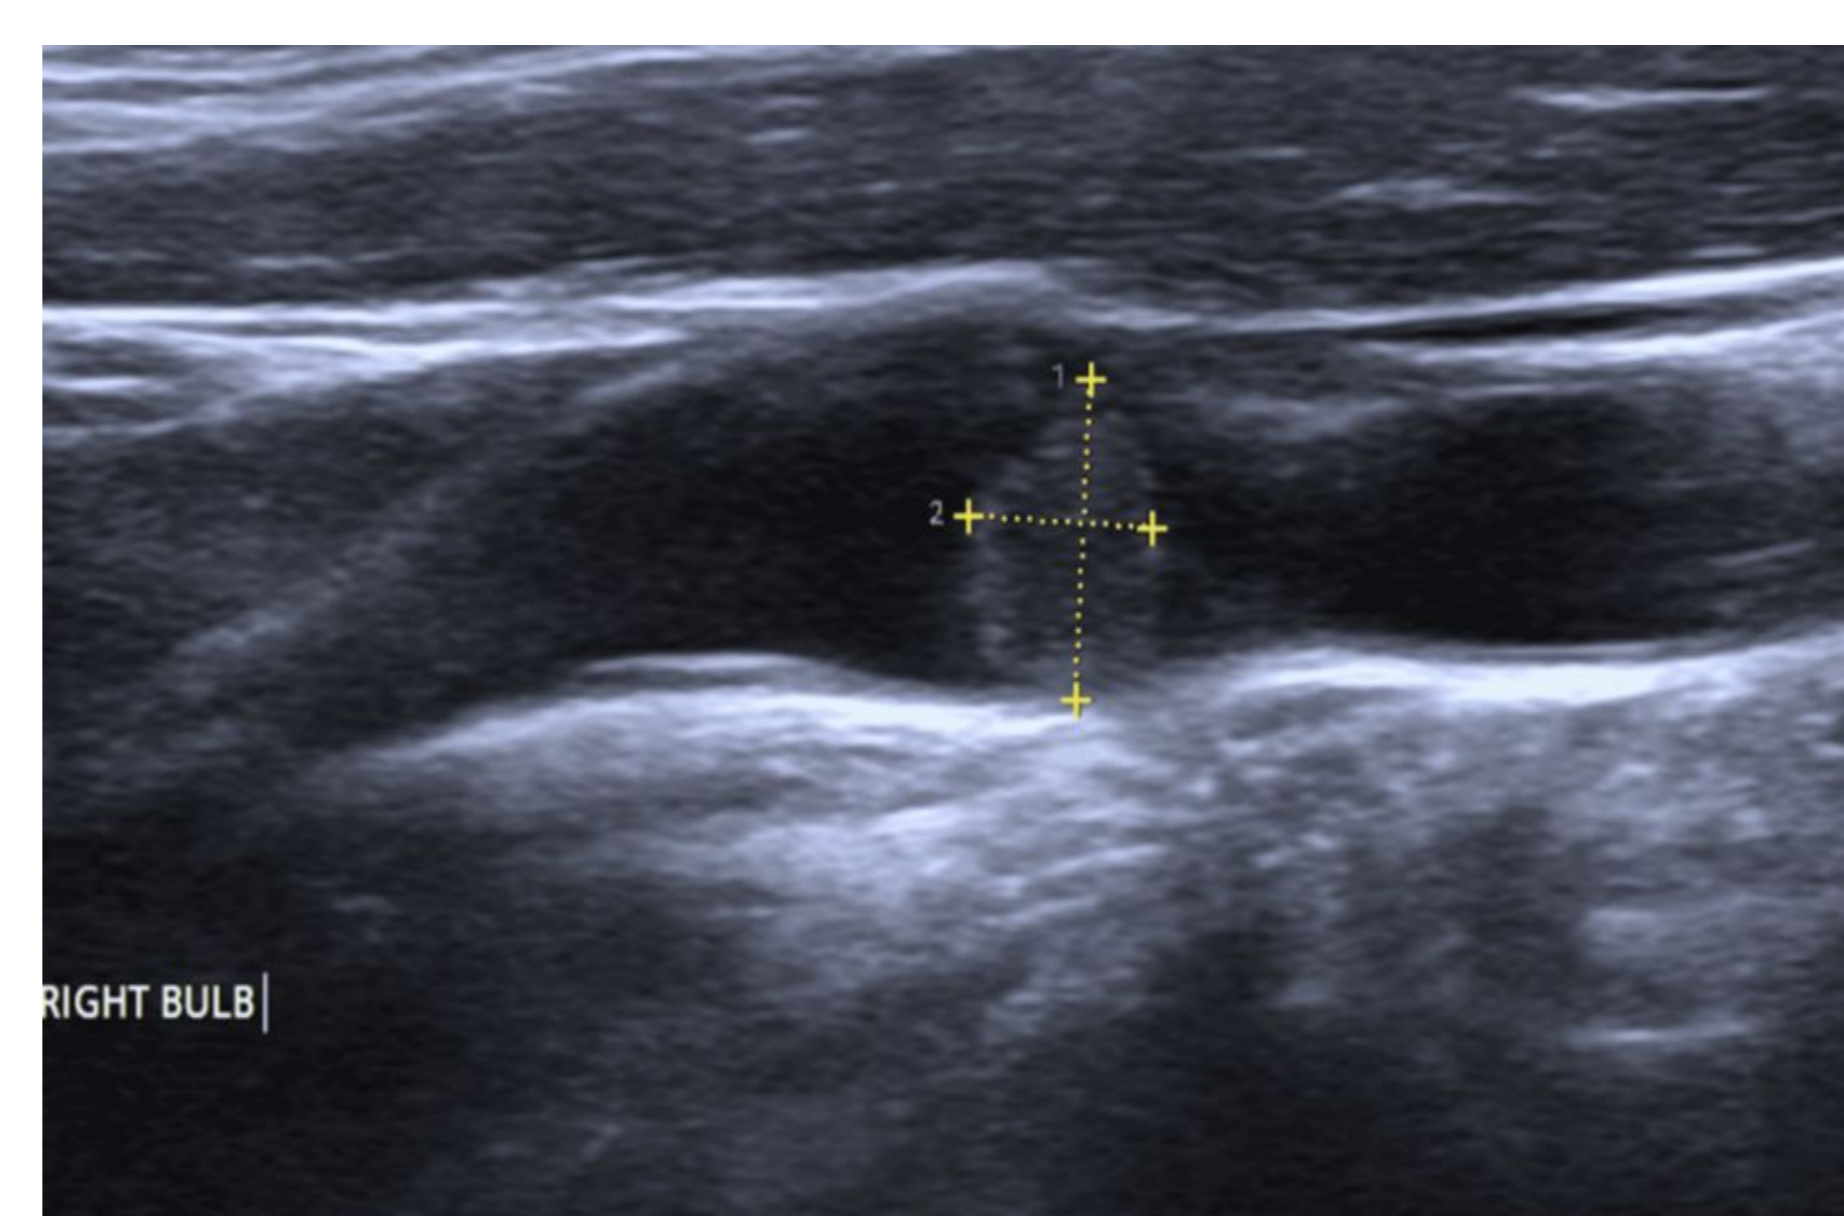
Carotid artery ultrasound
